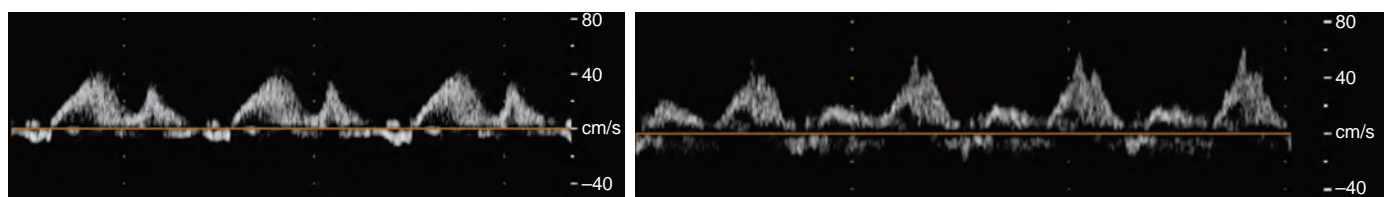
Pulmonary venous blood flow velocity waveforms obtained using pulsed-wave Doppler echocardiography under normal conditions (left) and during increased left atrial pressure (right).
